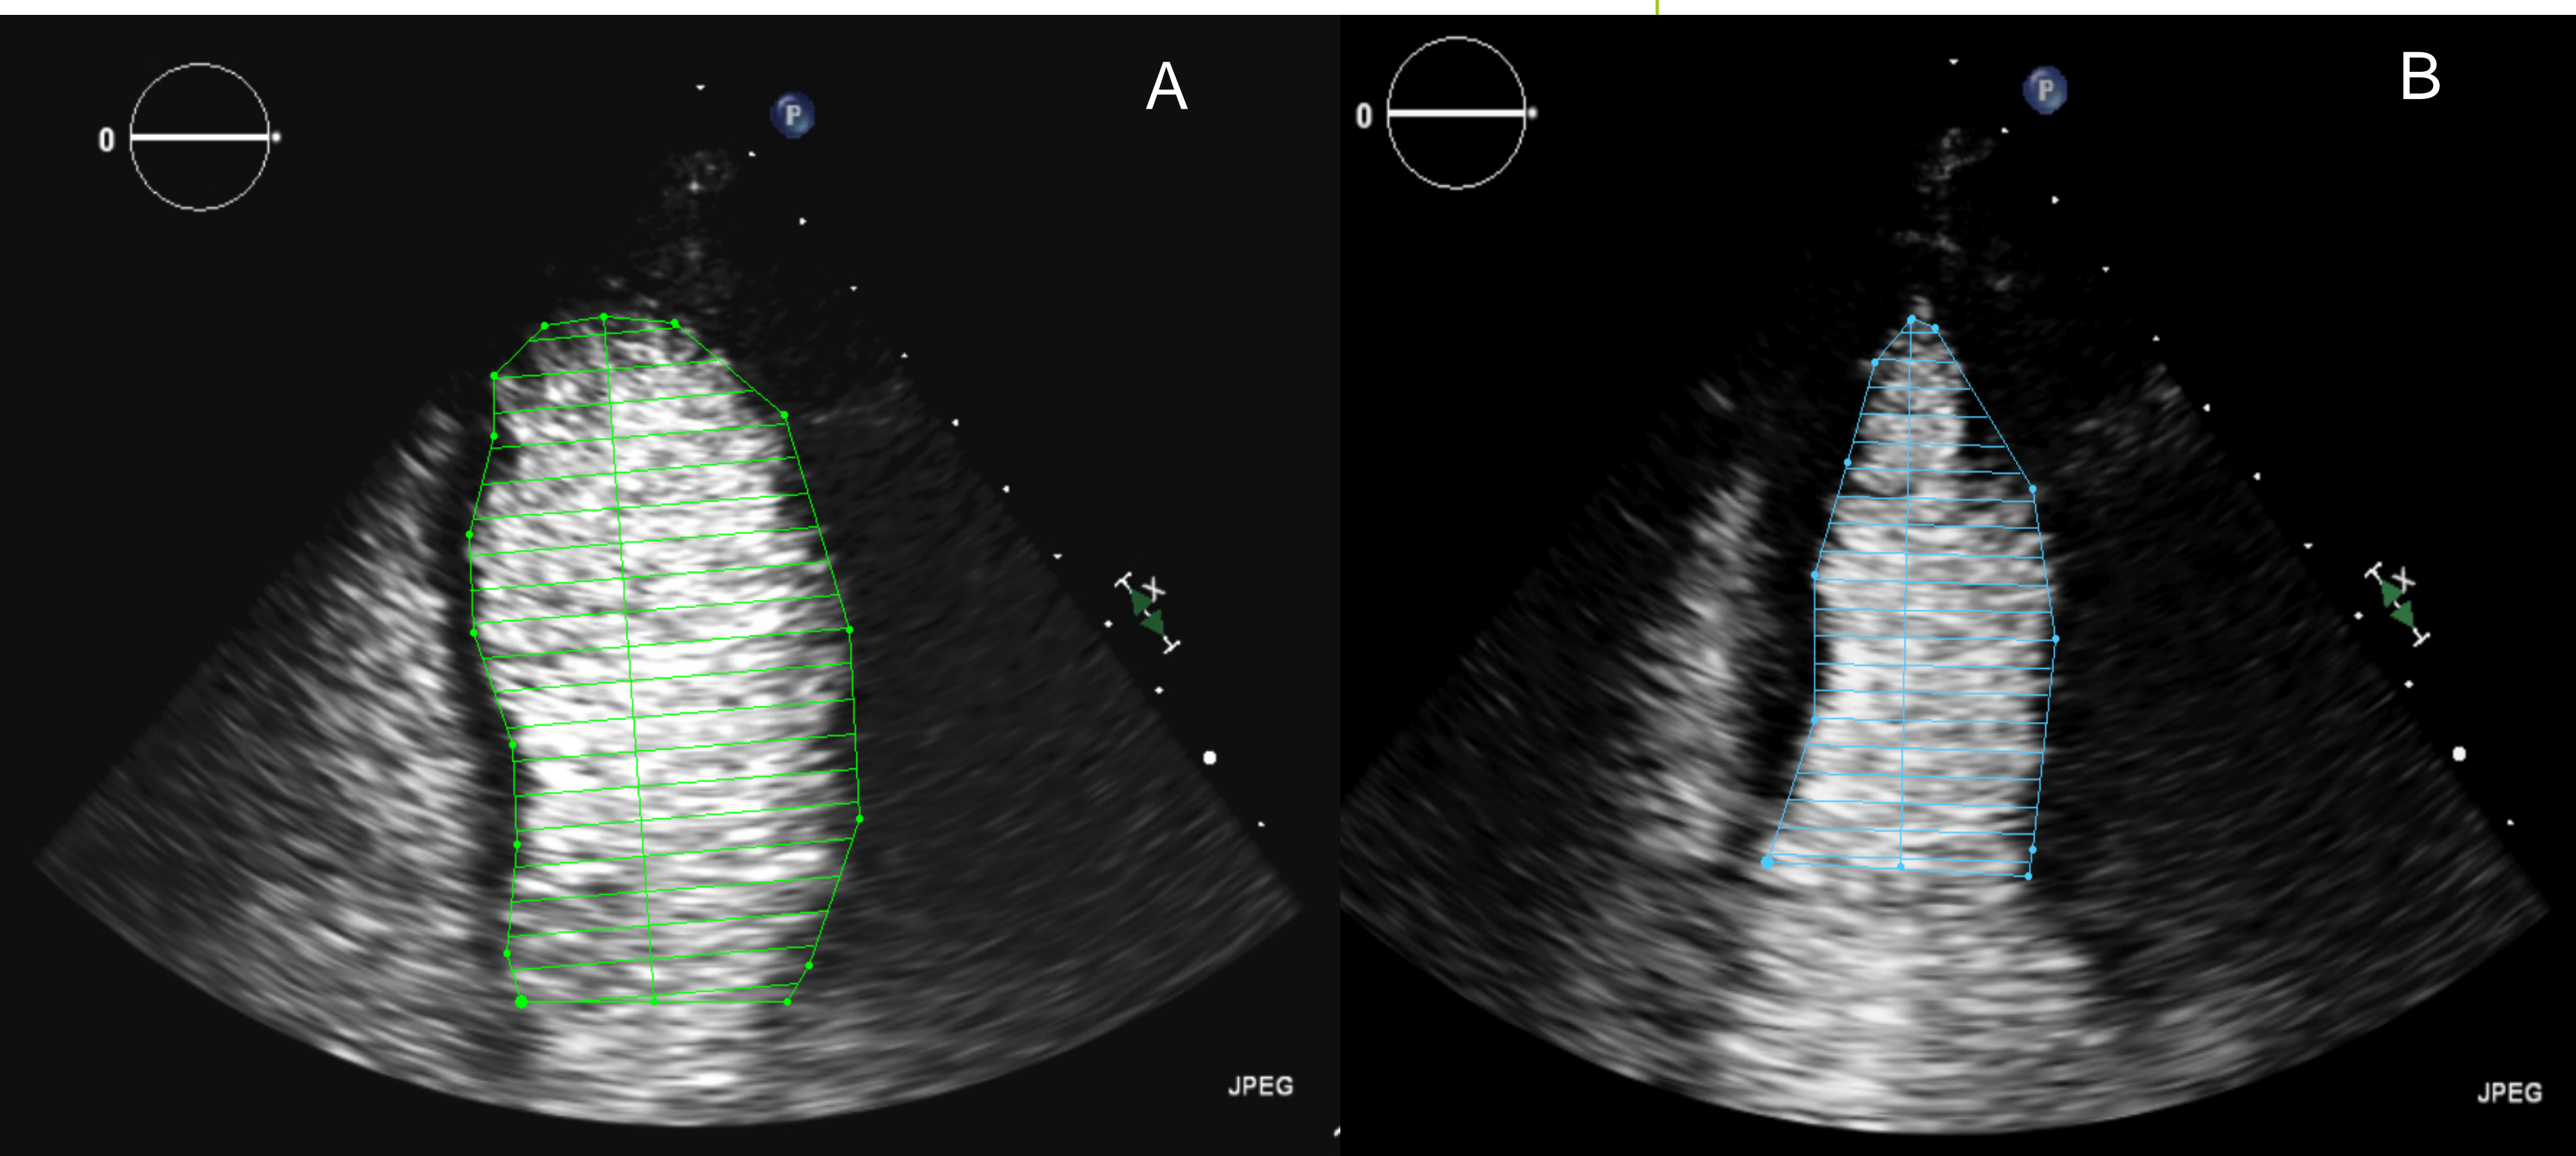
Apical 4Ch of CE-2DE in the end of Diastole (A). Apical 4Ch of CE-2DE in the end of Systole(B)
